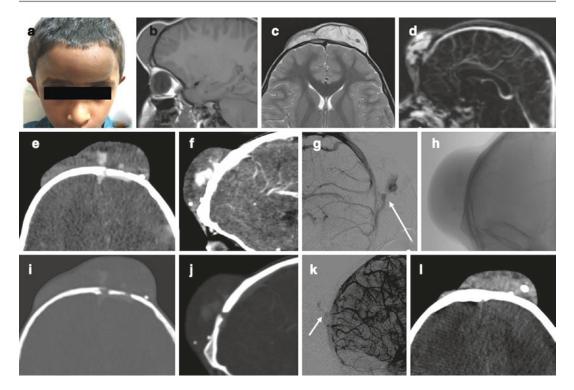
Four-year-old boy with swelling in the forehead noticed since 1 year of age and gradually progressive. (a) Clinical photograph showing the forehead swelling. (b, c) MRI images in T1WI and T2 WI sequence showing the venous malformation. (d) Contrast MR venography showing the sinus pericranii with contrast puddling in the malformation. (e, f, g, h) CT venous phase in Brain and bone window and axial and sagittal views respectively showing the bony defect with sinus peicranii. (i, j, k) Cerebral angiography in the venous phase documenting the communication. (l). CT showing Phlebolith
